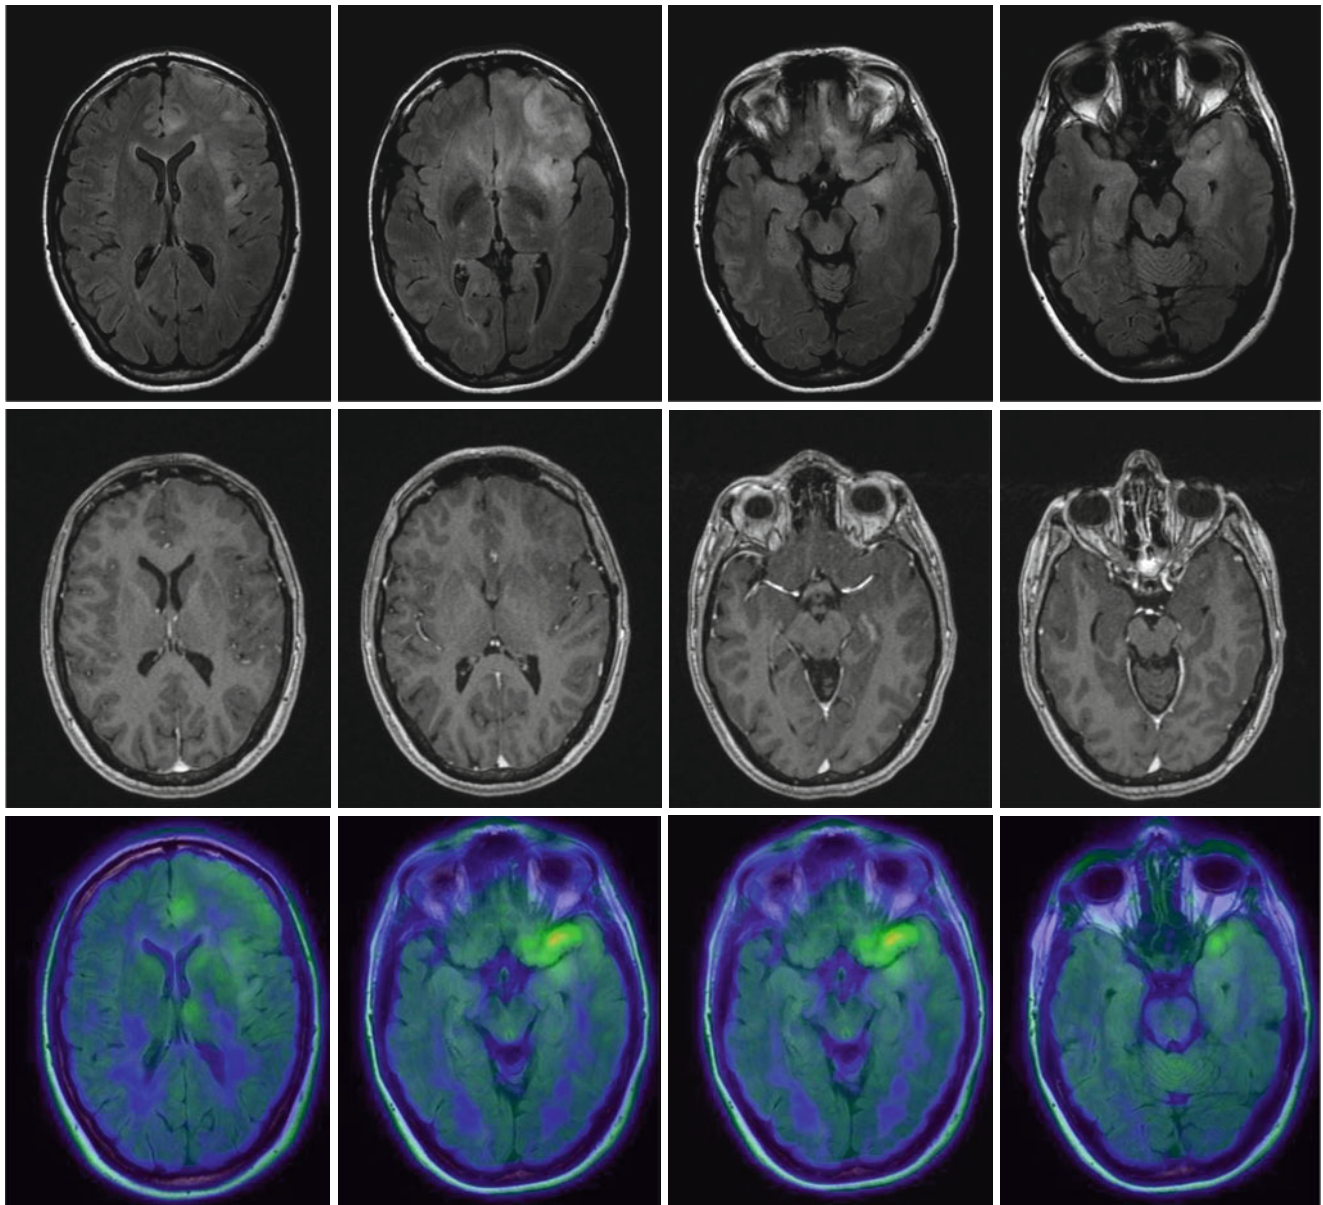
Low-grade gliomatosis with metabolic hot spots demonstrated by PET; female, 45 years. – FLAIR (*top*), contrast-enhanced T1 (*middle*), and ^{18}F ET-PET (*bottom*) (Courtesy of the Institute of Clinical Radiology and Clinic for Nuclear Medicine, Münster)
